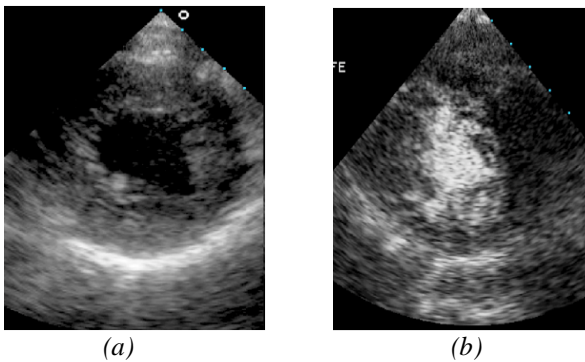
(a) Normal Ultrasound Image (b) Contrast Enhanced Ultrasound
